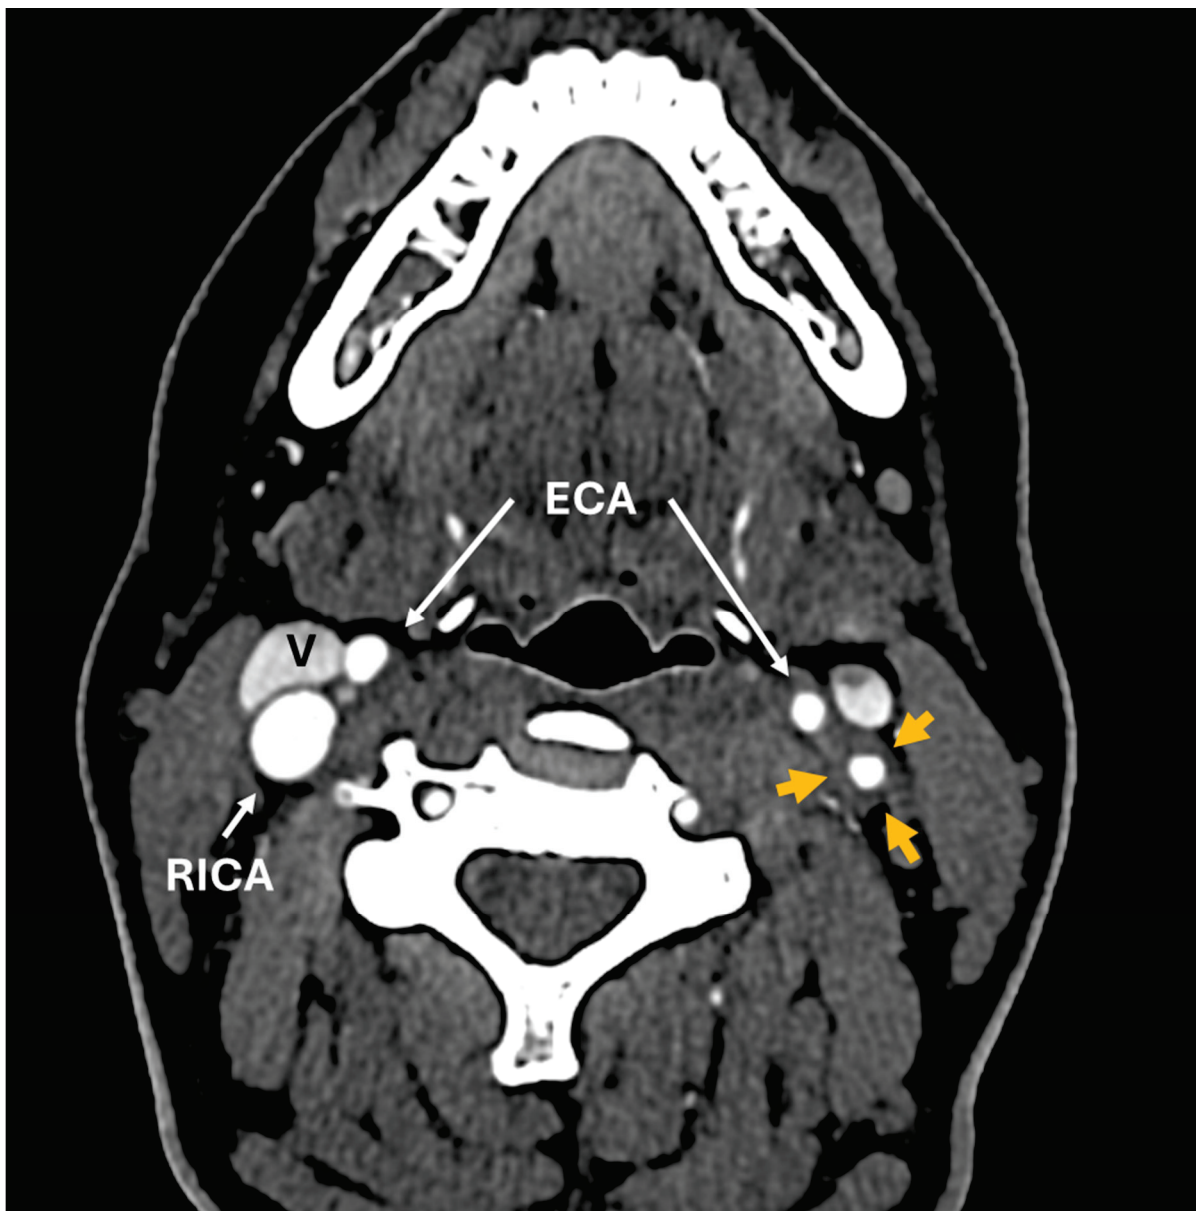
CT angiogram. Axial images above the level of carotid bifurcation show diffuse circumferential thickening of common carotid artery (CCA) and internal carotid artery (ICA) walls on the left side (orange arrows). Compare this to the normal wall thickness of the right carotid artery. White arrows point to the right common carotid artery (RCCA), right internal carotid artery (RICA) and bilateral external carotid arteries (ECAs). Internal jugular veins: (V). A repeat CT neck angiogram with contrast revealed a left-sided diffuse circumferential rim of soft tissue thickening involving the left carotid artery, which was concerning with respect to large-vessel vasculitis. It is unclear how long the carotid bulb thickening had been present.
